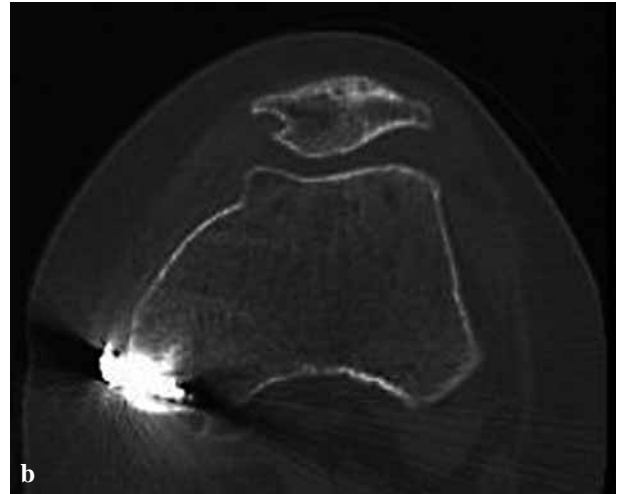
a) Preoperative axial CT-scan. Subluxation and abnormal congruence angle ; b) Postoperative CT-scan. Semitendinosus plasty and normal congruence angle.
